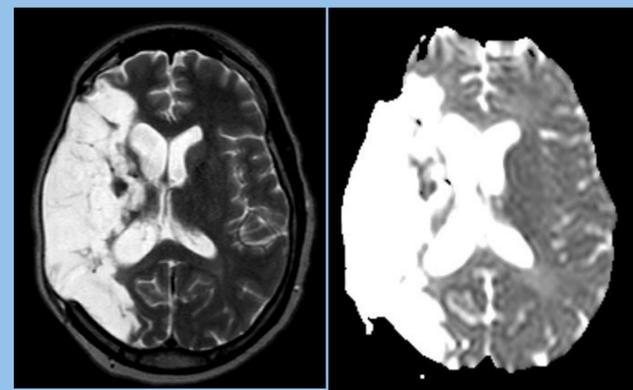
Magnetic resonance imaging done at 5 months follow up showing right chronic middle cerebral artery territory infarct in T2 and ADC sequences respectively
